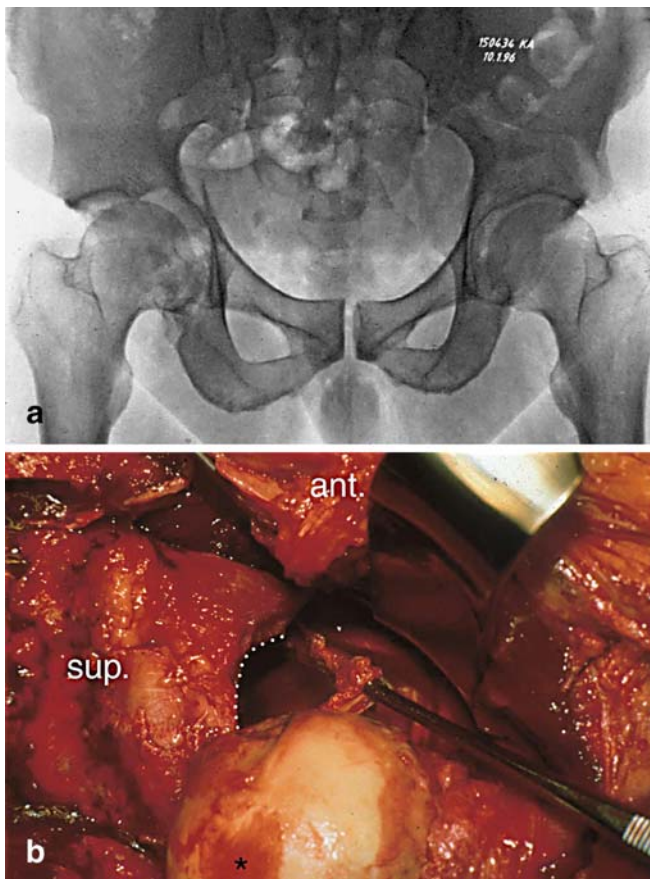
a Anteroposterior pelvic radiograph of a male patient (case 11) with medially displaced femoral head and inferior fragment in a transverse acetabular fracture of the right hip. b Intraoperative photograph of the same patient showing a hemicircular labral avulsion (probed by a forceps) from the superior acetabular rim (white dots). Note the cartilage lesion (case 11) seen on the femoral head (black star)
